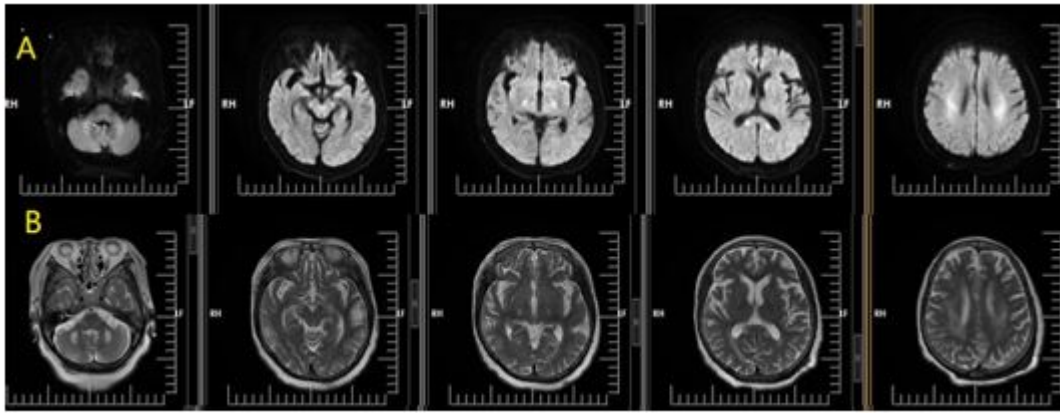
Magnetic resonance imaging (MRI) findings. A) Diffusion-weighted imaging MRI showed symmetrical bilateral lesion in the cerebellar peduncle, cerebral peduncle, posterior limbs of the internal capsules, corpus callosum and corona radiata. B) T2-weighted MRI showed hypertension in these lesions.
